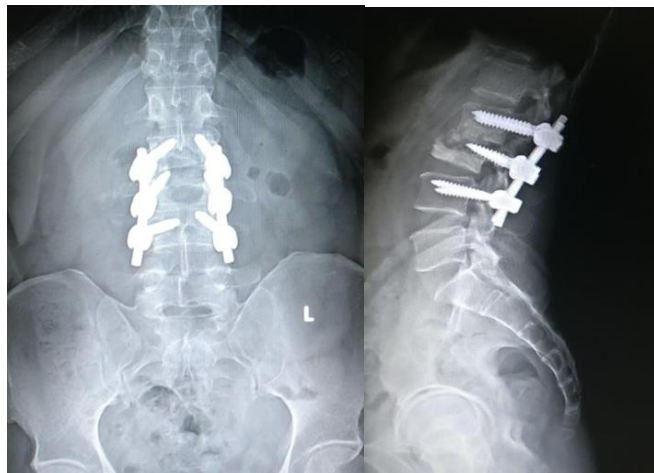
Radiograph at final follow up showing good healing
